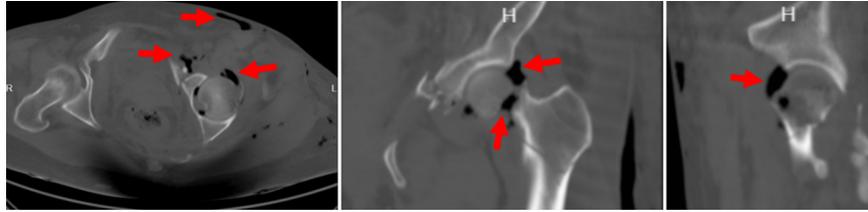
Pelvic CT revealed the 'free black air bubble sign', indicates external air invasion and the presence of a superficial wound.
